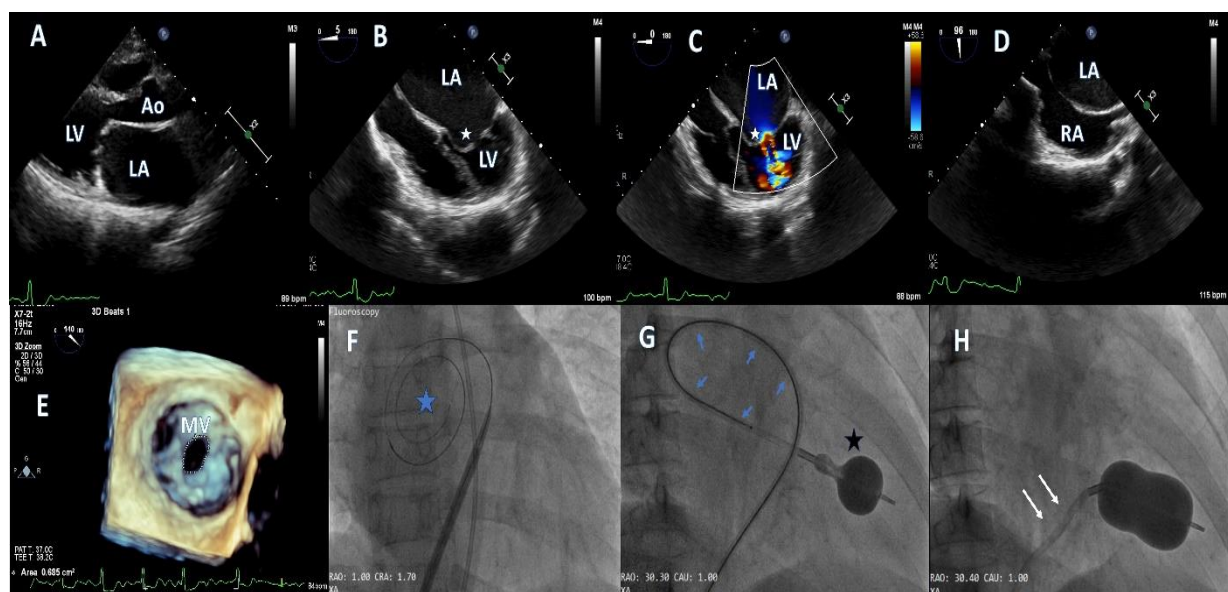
A-E: ECHOCARDIOGRAPHIC IMAGES
